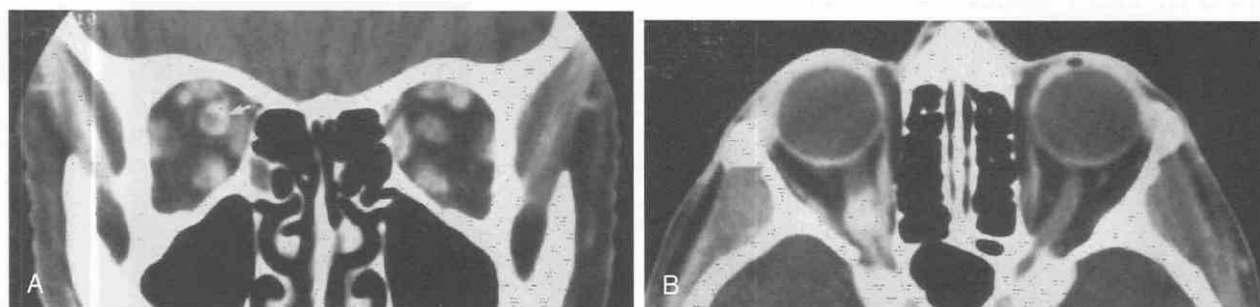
A, Coronal contrast-enhanced CT scan shows optic nerve sheath meningioma (arrow). B, Axial contrast-enhanced CT scan shows same patient as in A.
